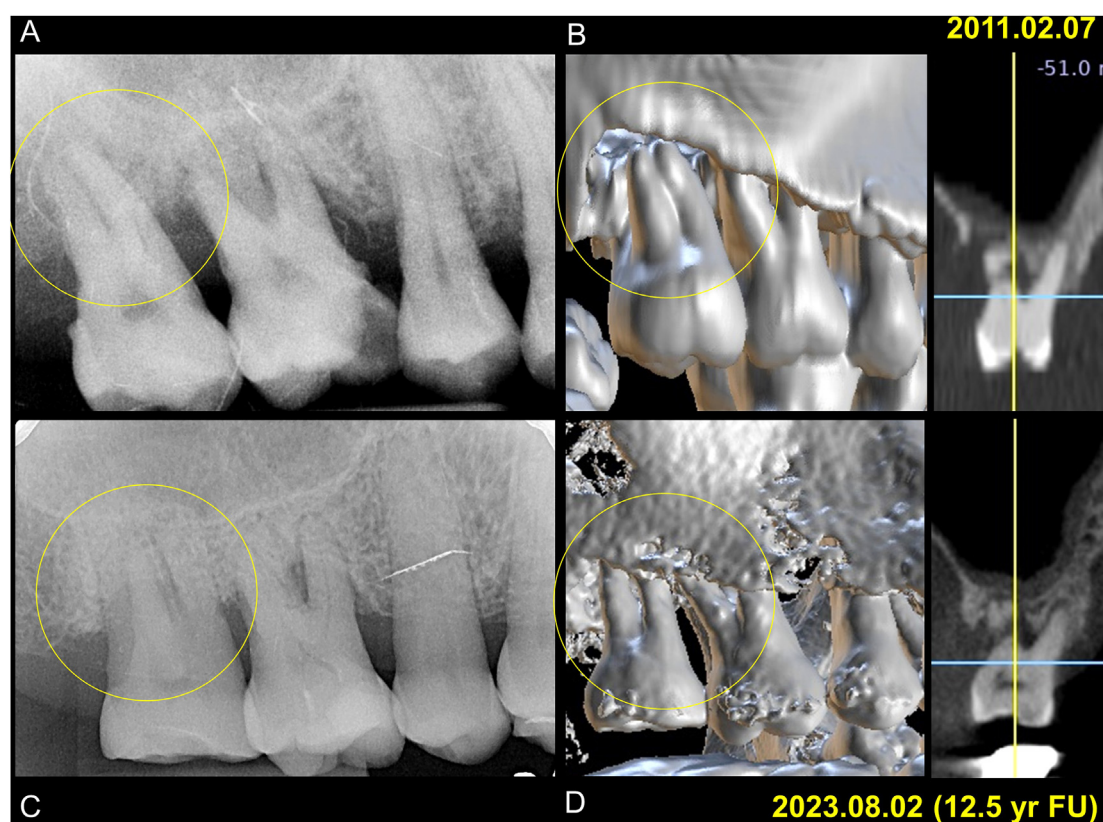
Case 2 involves a 40-year-old female patient diagnosed with Stage IV periodontitis, presenting with crowded posterior teeth, diastema, flare-out of anterior teeth, and severe bone loss. Clinical probing depths of teeth #16 and #17 measured 6–7 mm. Regenerative therapy was utilized to reconstruct lost periodontal tissues. Both periapical radiographs taken initially (Fig. 3A) and at the last follow-up (Fig. 3B) and a cone-beam computed tomography (CBCT) scan conducted initially (Fig. 3C) and 12.5 years after periodontal regenerative treatment (Fig. 3D) revealed significant filling of the intrabony defect of tooth #17 at both the buccal and palatal sides, accompanied by an increase in bone density.
